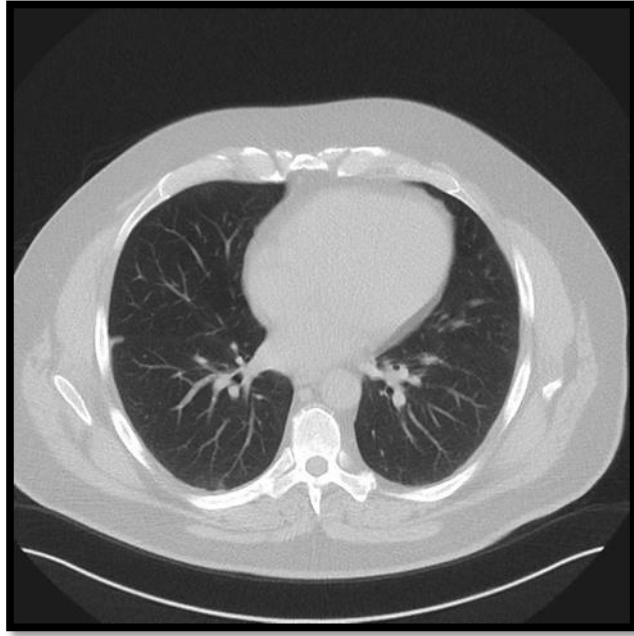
(show normal HRCT lungs)
